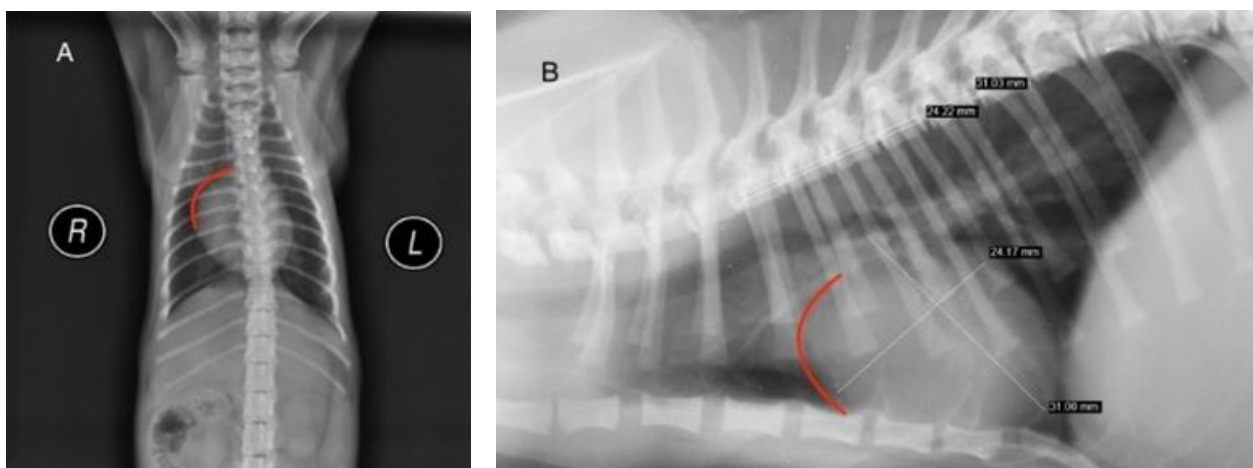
ASD radiographic images in (A) Ventrodorsal and (B) lateral views. VHS measured from the lateral view was 9 which indicates cardiac enlargement. Right atrial enlargement is shown with the curve lines in both views.
